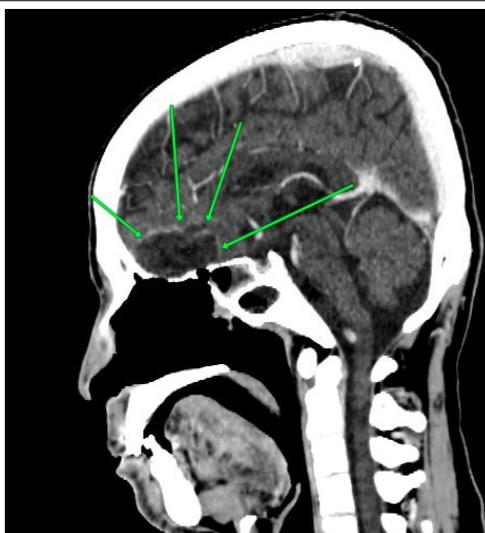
Computed Tomography (CT) scan of head without contrast injection, sagittal plane depicted hypodense lesion, as a low-density area with a surrounding ring of enhancement on the cerebral frontal associated with surrounding edema.
